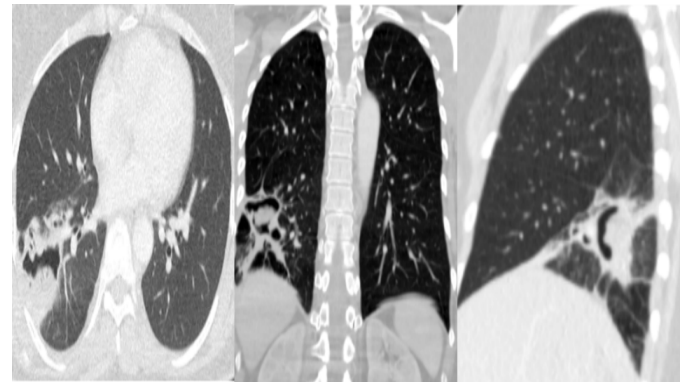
Preoperative computerized thorax CT image (A: axial view B: coronal view C: Sagittal view).
